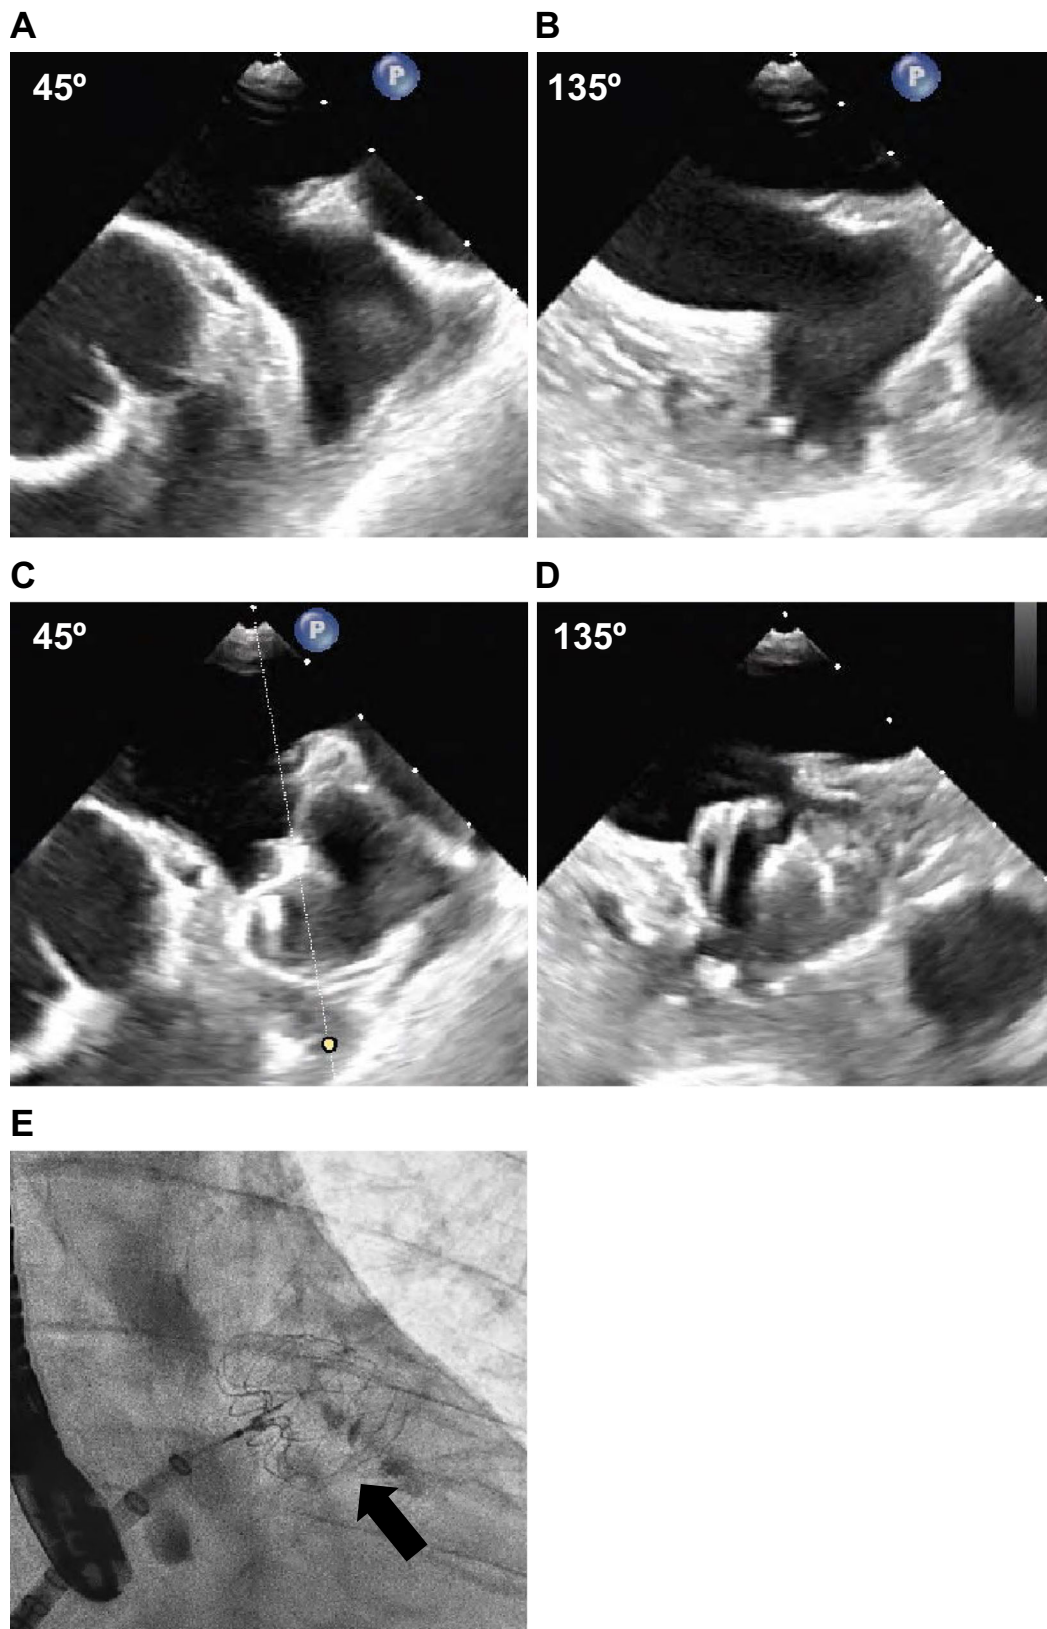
Two-dimensional transesophageal echocardiography image of left atrial appendage before procedure showed normal left atrium without thrombus (A, B). Subsequently, the deployed left atrial appendage closure device (30-mm WATCHMAN™) was confirmed with transesophageal echocardiographic imaging (C, D) and fluoroscopic imaging (E).
